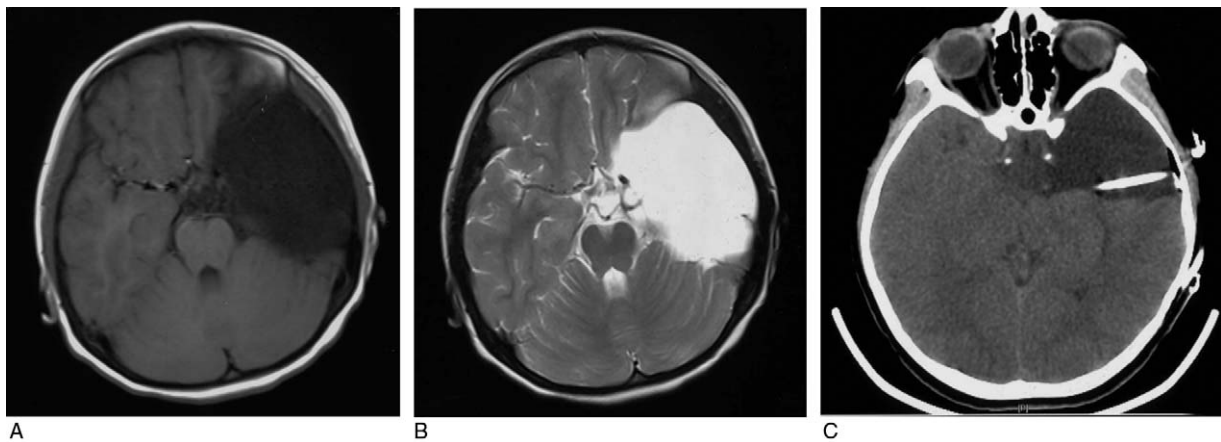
Radiological examination of the proband. Preoperative T1-weighted (A) and T2-weighted (B) MRI show an arachnoid cyst in the left anterior and middle cranial fossa. Follow-up CT 8 months postoperatively shows that the size of the cyst was significantly reduced (C). CT = computed tomography, MRI = magnetic resonance imaging.
